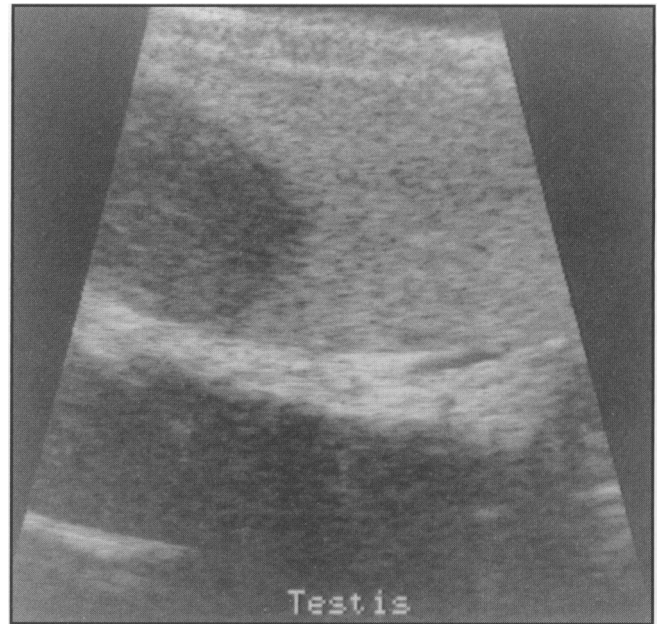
Ultrasound appearance of testicular seminoma.
